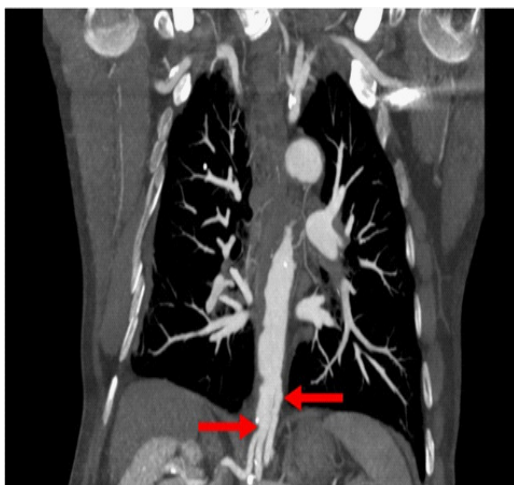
CT examination of the thorax, MPR reconstruction, frontal view – a typical location of the ostium celiac artery and the common trunk of the superior mesenteric artery and renal arteries above the level of the diaphragm.
